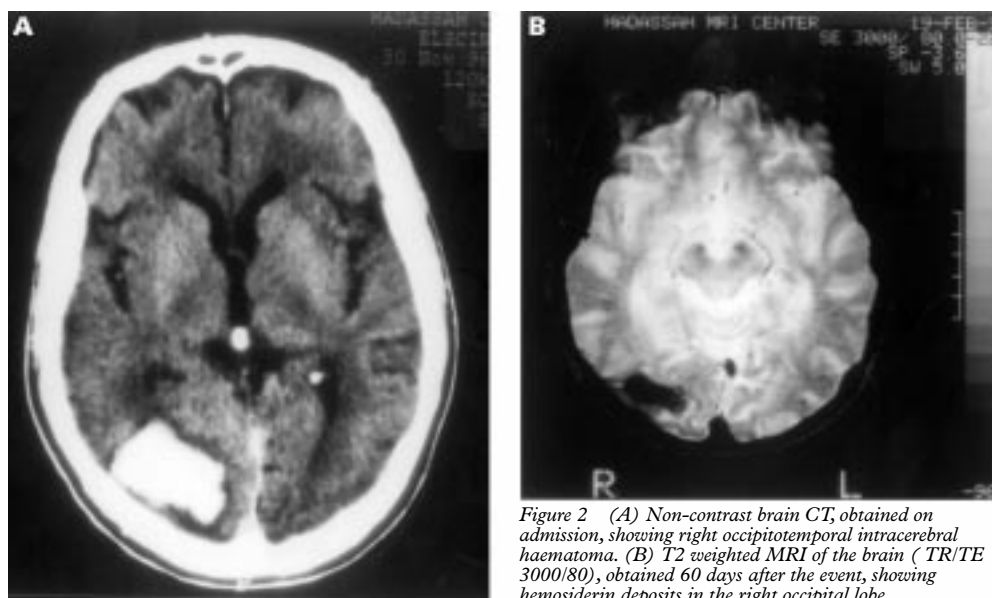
(A) Non-contrast brain CT, obtained on admission, showing right occipitotemporal intracerebral haematoma. (B) T2 weighted MRI of the brain (TR/TE 3000/80), obtained 60 days after the event, showing hemosiderin deposits in the right occipital lobe.
